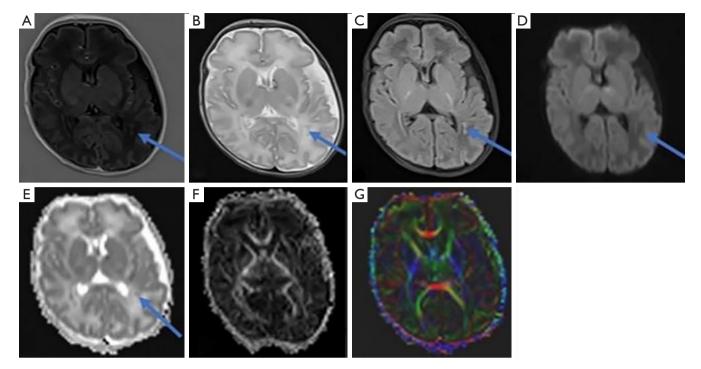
Male, premature infant with necrotizing enterocolitis and a corrected gestational age of 34 weeks. There is punctate lesion near the posterior corner of the left lateral ventricle (blue arrows). (A) T_1WI shows a slightly high signal. (B) T_2WI shows a slightly low signal. (C) T_2 -FLAIR shows a slightly high signal high signal shadow. (E) The MD map is a low signal, (F,G) FA image and color FA image. T_1WI , T_1 -weighted image; T_2WI , T_2 -weighted image; T_2 -FLAIR, T_2 fluid-attenuated inversion recovery; DWI, diffusion-weighted imaging; MD, mean diffusivity; FA, fractional anisotropy.
